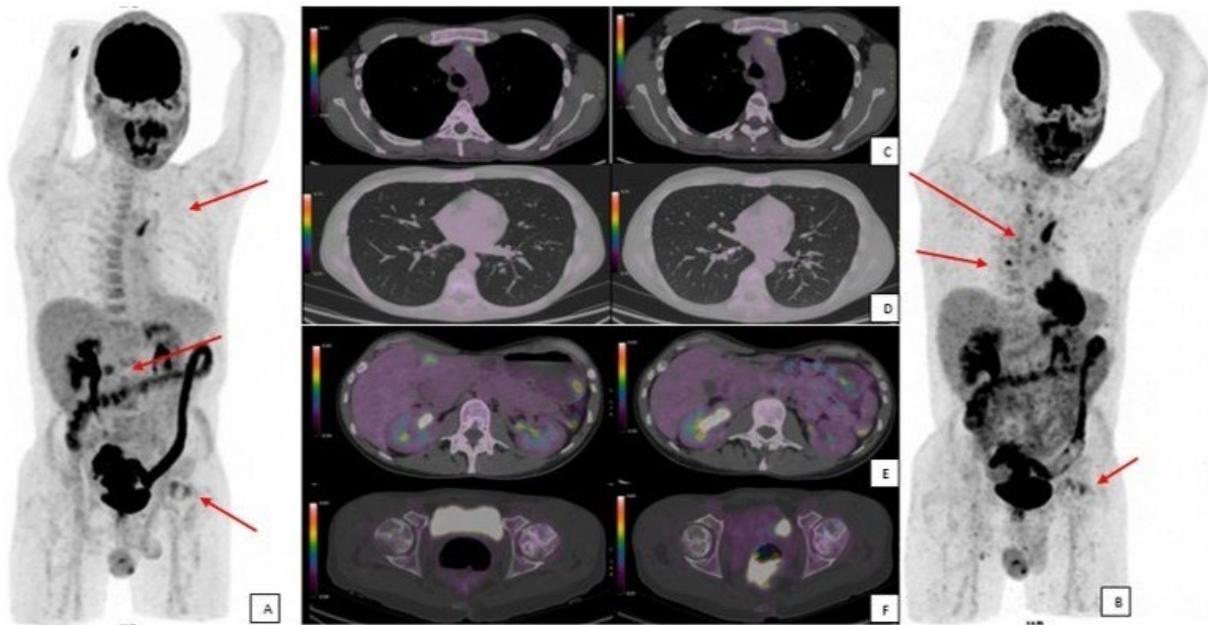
PET-CT with 18F-FDG of a 27-year-old male patient with medullary thyroid cancer plus multiple metastases. (A) Baseline MIP showing evidence of liver metastasis (B) Re-staging MIP showing disease progression at the nodal, pulmonary and bone level, as well as good response at the hepatic level. (C, D and E) PET-CT in axial slices at the level of the mediastinum, pulmonary, liver and left femur, showing morphological and metabolic progression.
